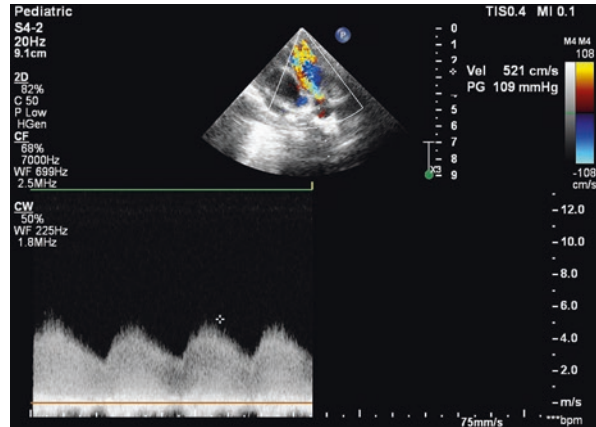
The continuous Doppler signal registered through the PDA in the same patient
